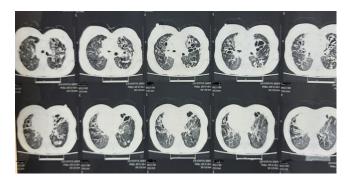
HRCT chest sections showing cystic dilatation of bronchus with thickened bronchial wall suggestive of bronchiectasis at both lungs
